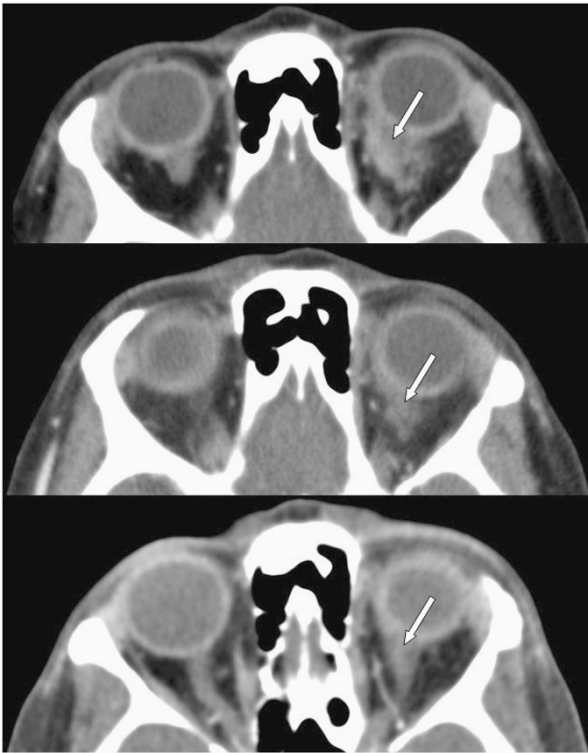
Left superior orbital mass (white arrow) in Case 1 significantly reduced in size following rituximab treatment. No abnormality detected at 2-year follow-up. Axial computed tomography pre-treatment (top); computed tomography at 2-month follow-up (middle); and computed tomography at 2-year follow-up (bottom).
